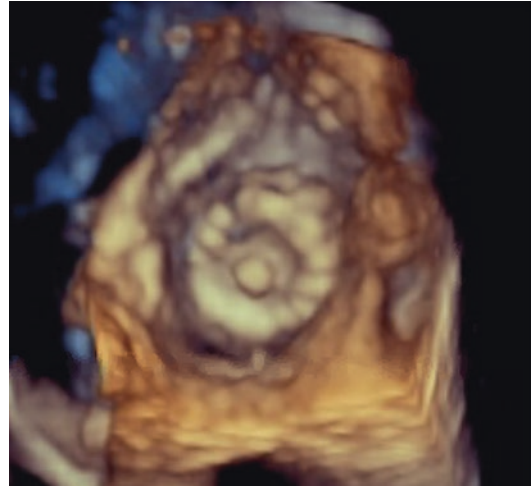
Another view of the occlusion device by 3D echocardiography
